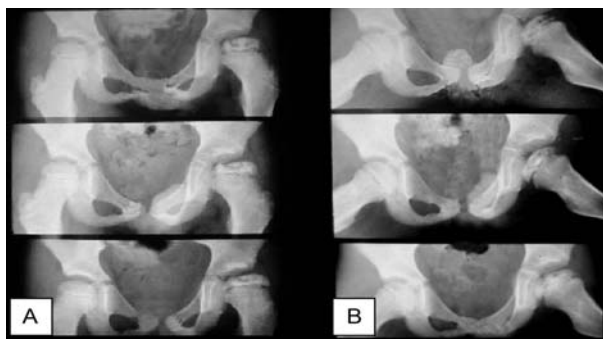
A - Patient at disease's fragmentation phase. B - Evolving with reossification of the lateral column characterized by the necrosis area disappearing from x-ray image.
